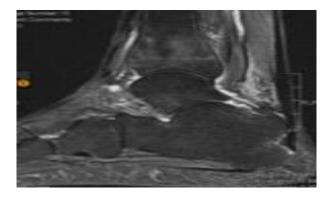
MRI scan with fracture healing.
